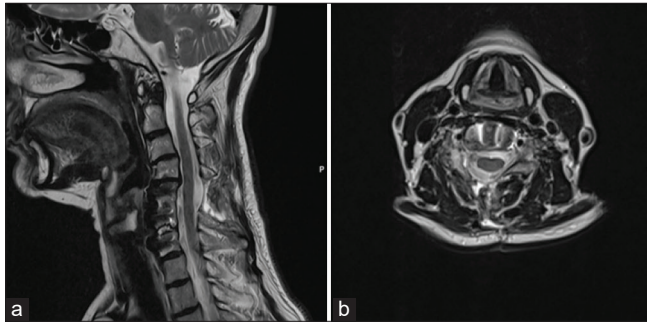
Postoperative sagittal (a) and axial (b) MRI T2-weighted scans one month after surgery revealed a complete tumor removal.
